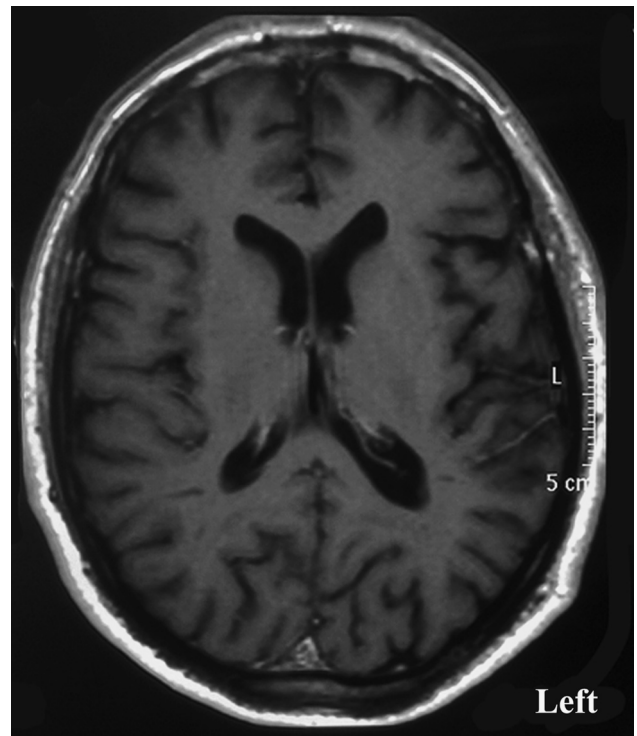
Patient's MRI of the brain. Structural image shows mild atrophy of the left perisylvian region.
